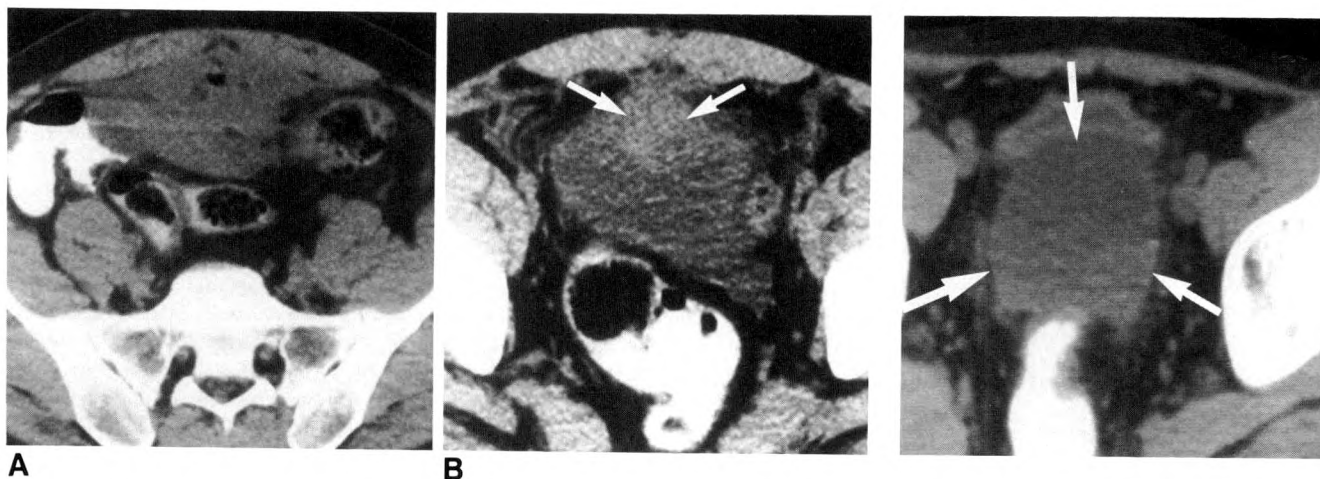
38-year-old man presenting with dysuria. Cystoscopy was negative. Small-bowel series showed thickening of small bowel without a fistula. CT shows abscess beneath anterior abdominal wall (arrows) extending to dome of bladder. At surgery a fistula was found into bladder wall but not into bladder. About 0.5 m of small bowel was resected but bladder was not.
